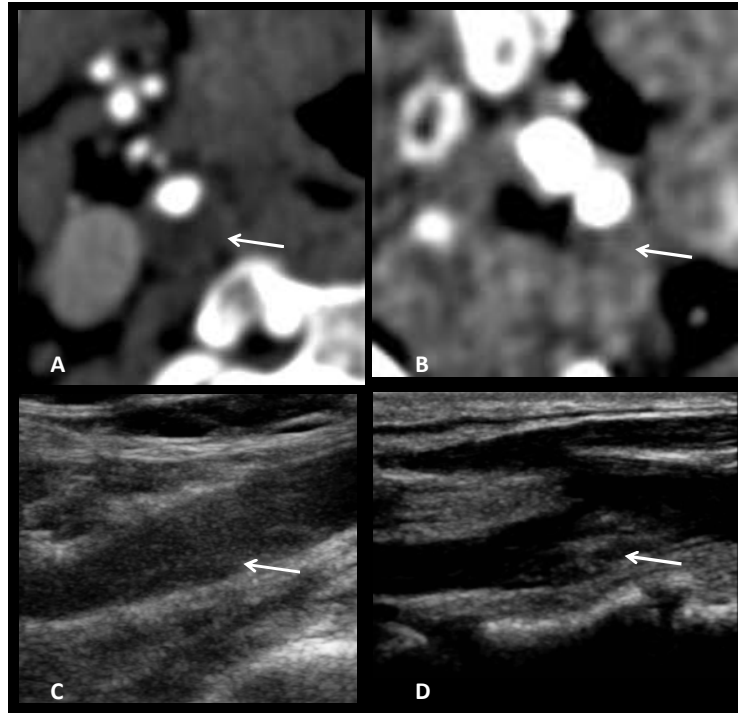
Attenuation of plaques as seen on CTA (A) 4.8 HU; (B) 66.1 HU; On B mode ultrasound (C) hypoechoic and (D) hyperechoic plaque
